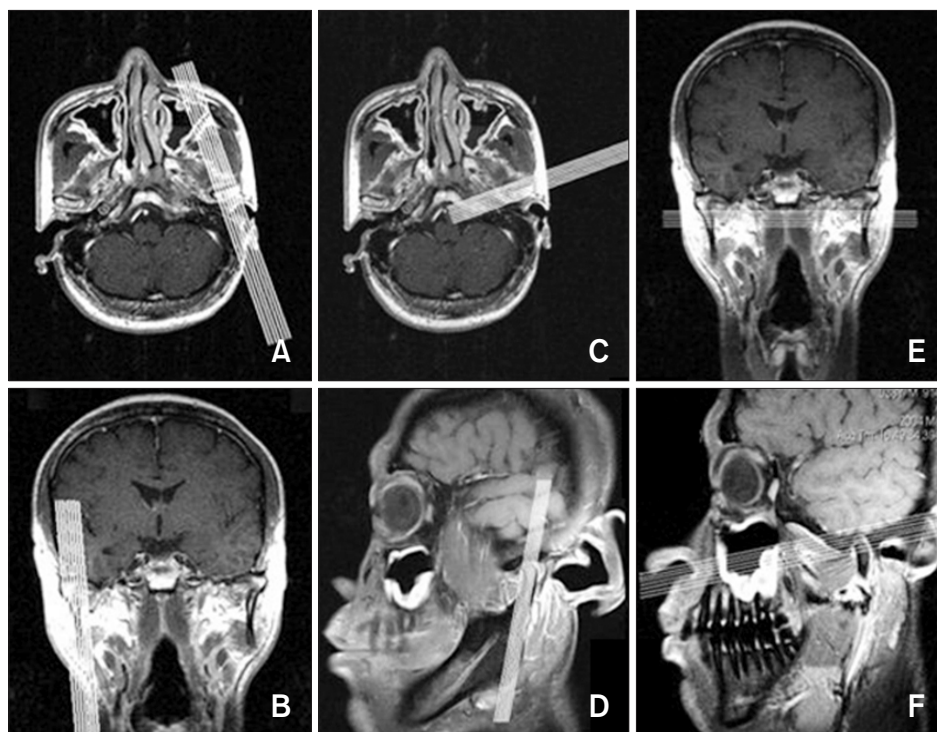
Magnetic resonance imaging (MRI) sections for temporomandibular disorder (TMD). All participants had taken several sections of MRI for TMD evaluation. (A, B) Para-sagittal section. (C, D) Para-coronal section. (E, F) Para-transverse section.
